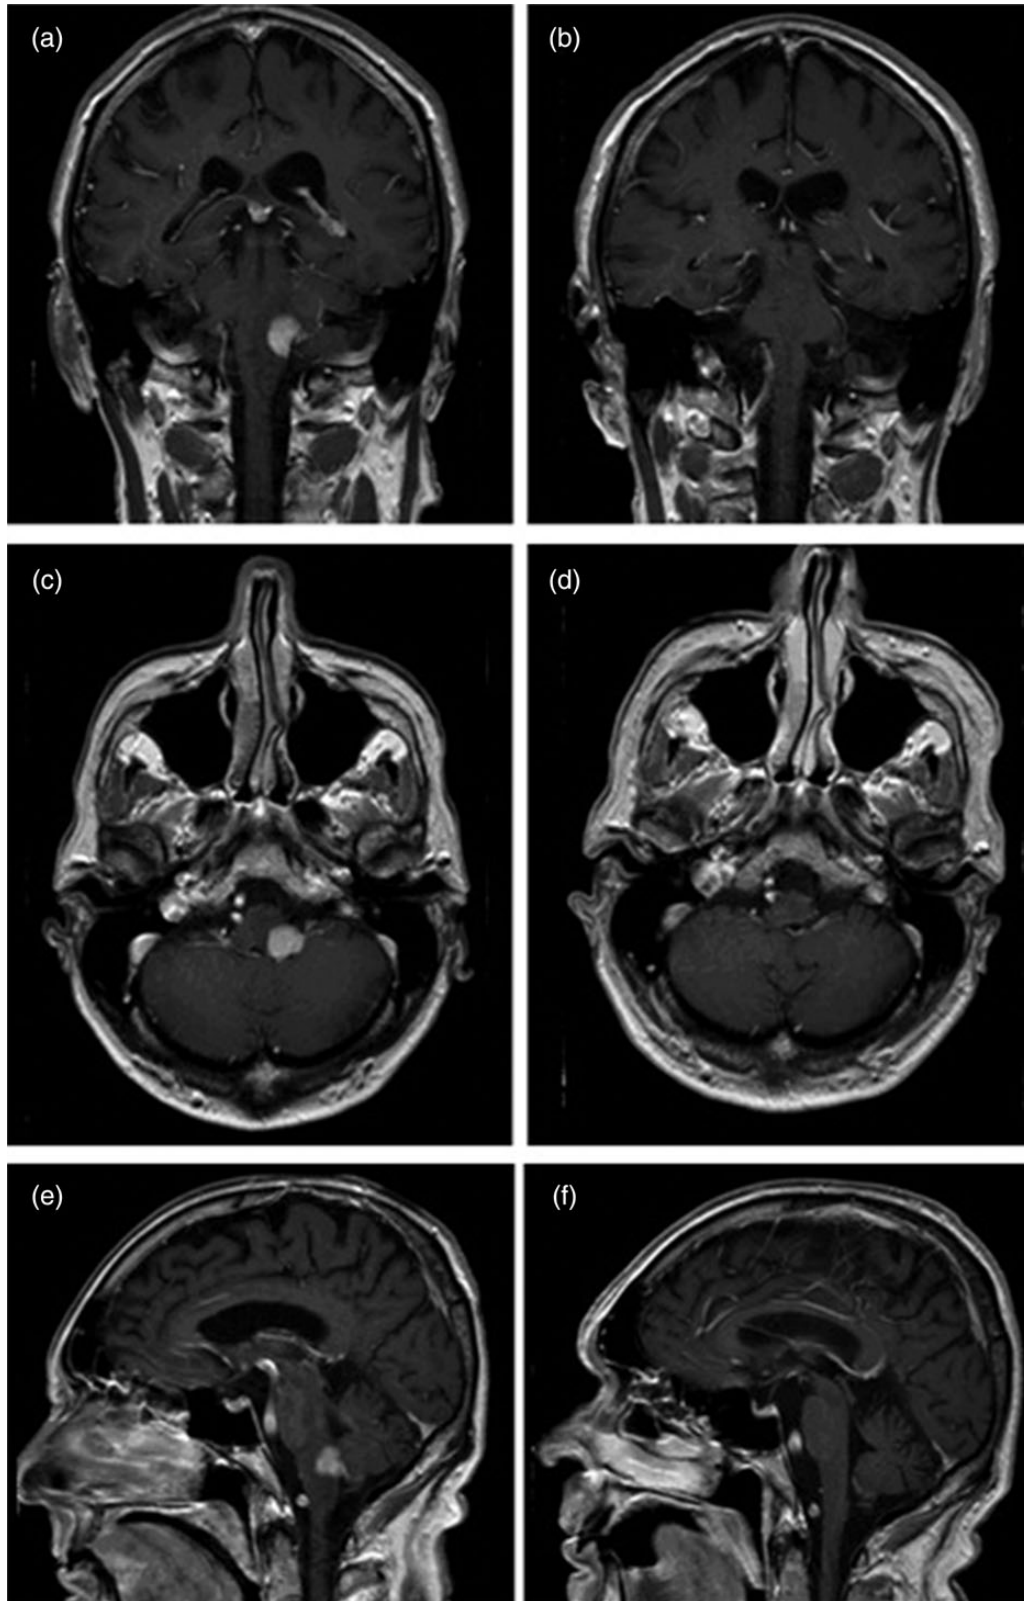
Compares initial T₁-weighted gadolinium-enhanced MRI images (seen in panes on left hand side: a, c and e) with those taken following completion of treatment (panes on right: b, d and f). Radiological remission is shown in the post-treatment images.
